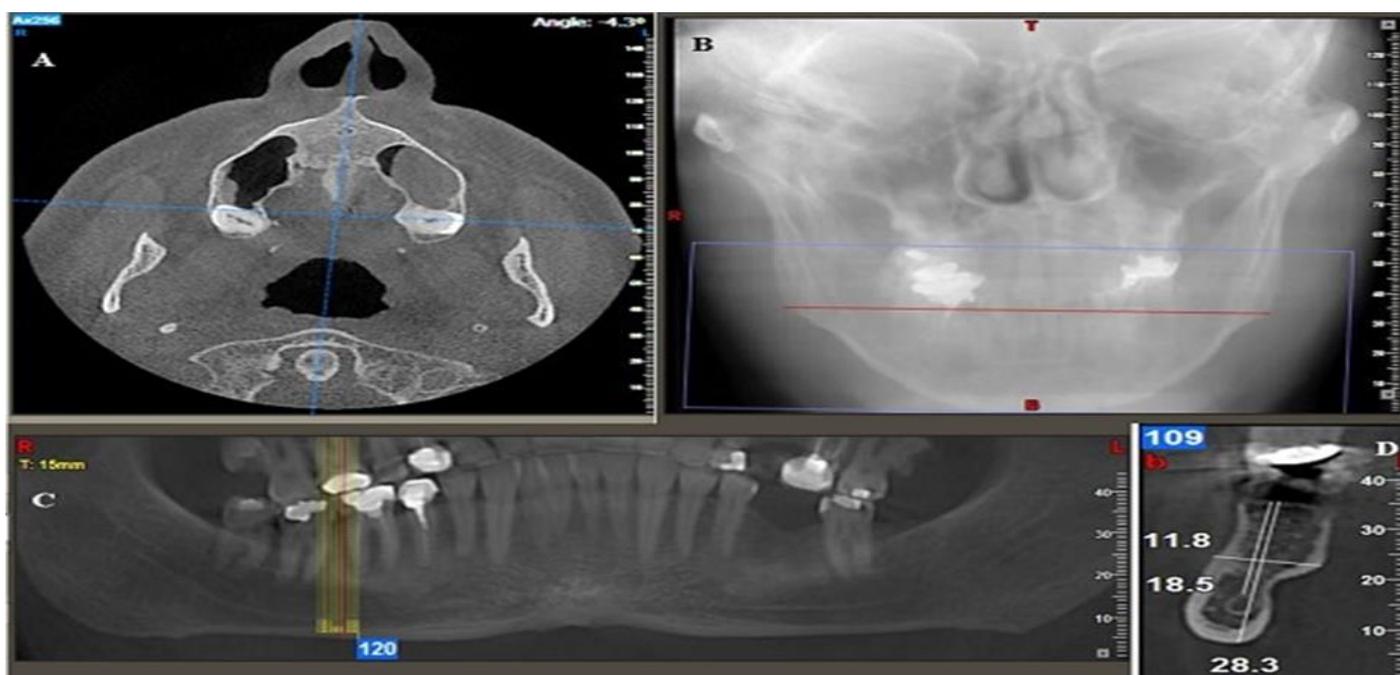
Neutral alignment of CBCT volume orientation in axial (A) and coronal planes (B). C) Selection of the cross-sectional slice at the interradicular region between the first and second mandibular molars. D) Measurement of alveolar bone width in the posterior mandible between the buccal and lingual cortical plates.
